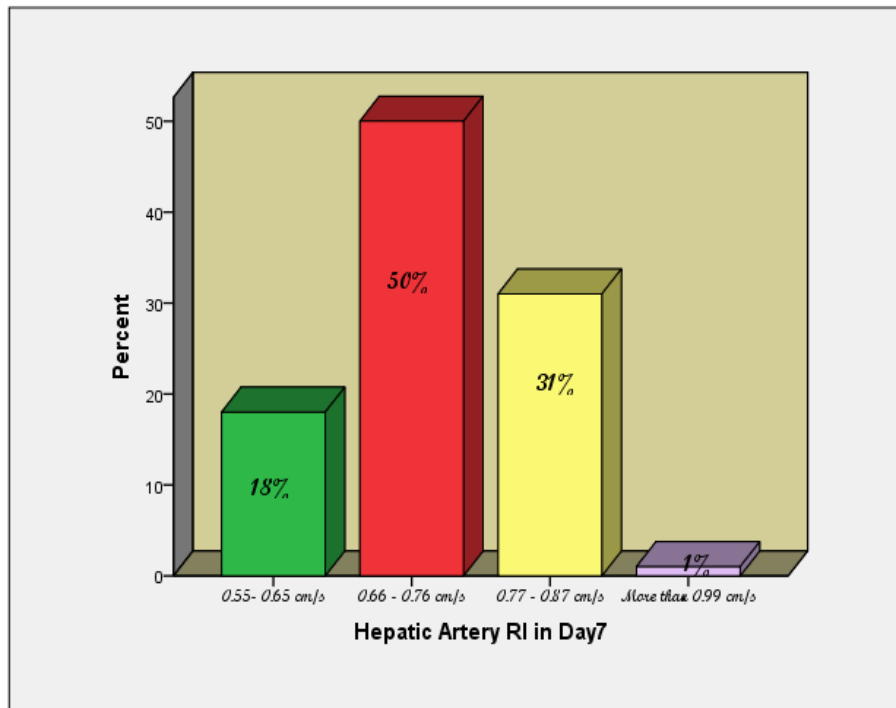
Frequency distribution of Doppler RI for hepatic artery in day 7
